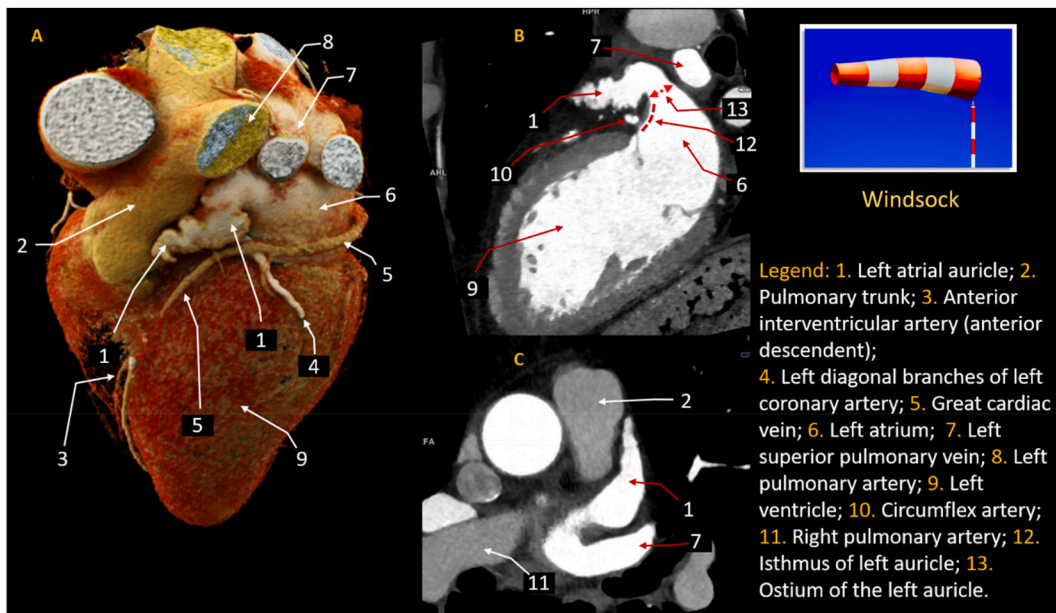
(A–C). Cinematic rendering (A) and multiplanar (B,C) CT reconstruction images of “windsock” LAA morphology.
